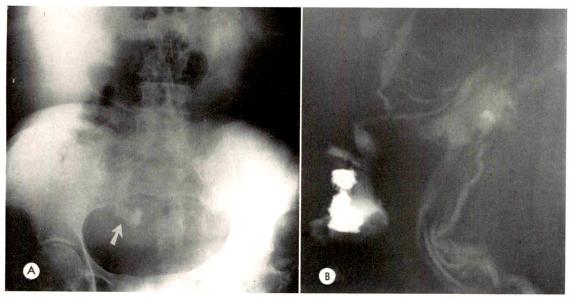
(A) Calcification in an adenocarcinoma of the appendix is seen on this antemortem supine roent-genogram of the abdomen. (Courtesy of Dr. Harry Z. Mellins.) (B) Roentgenogram of the appendix and ileocecal area at postmortem examination.
